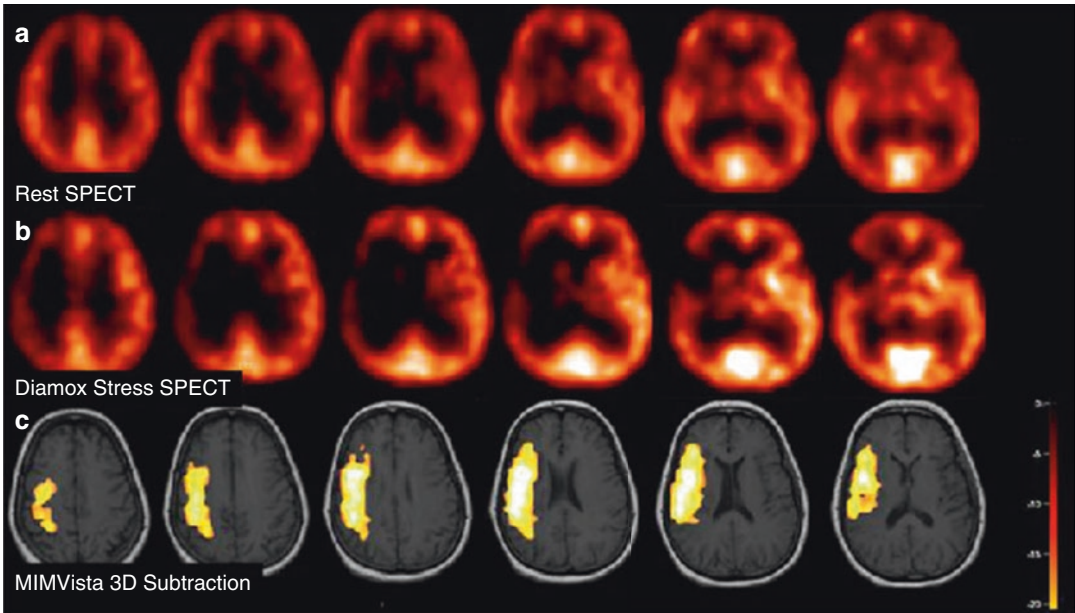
A 60-year-old female with transient left-sided weakness and facial droop. (a–c) Rest, stress, and 3D subtraction SPECT demonstrate relative decreased cerebral perfusion in right ICA territory between rest and stress states
